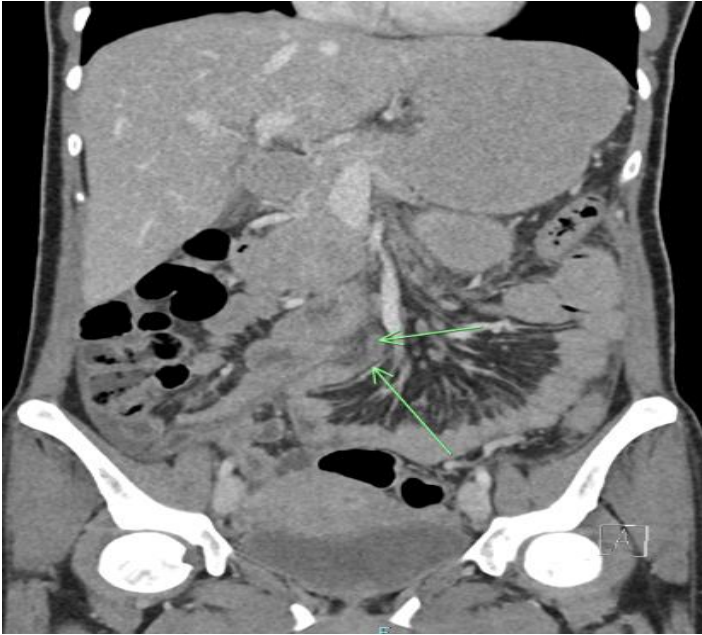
Coronal view on CT scan showing transition point at proximal small bowel.
